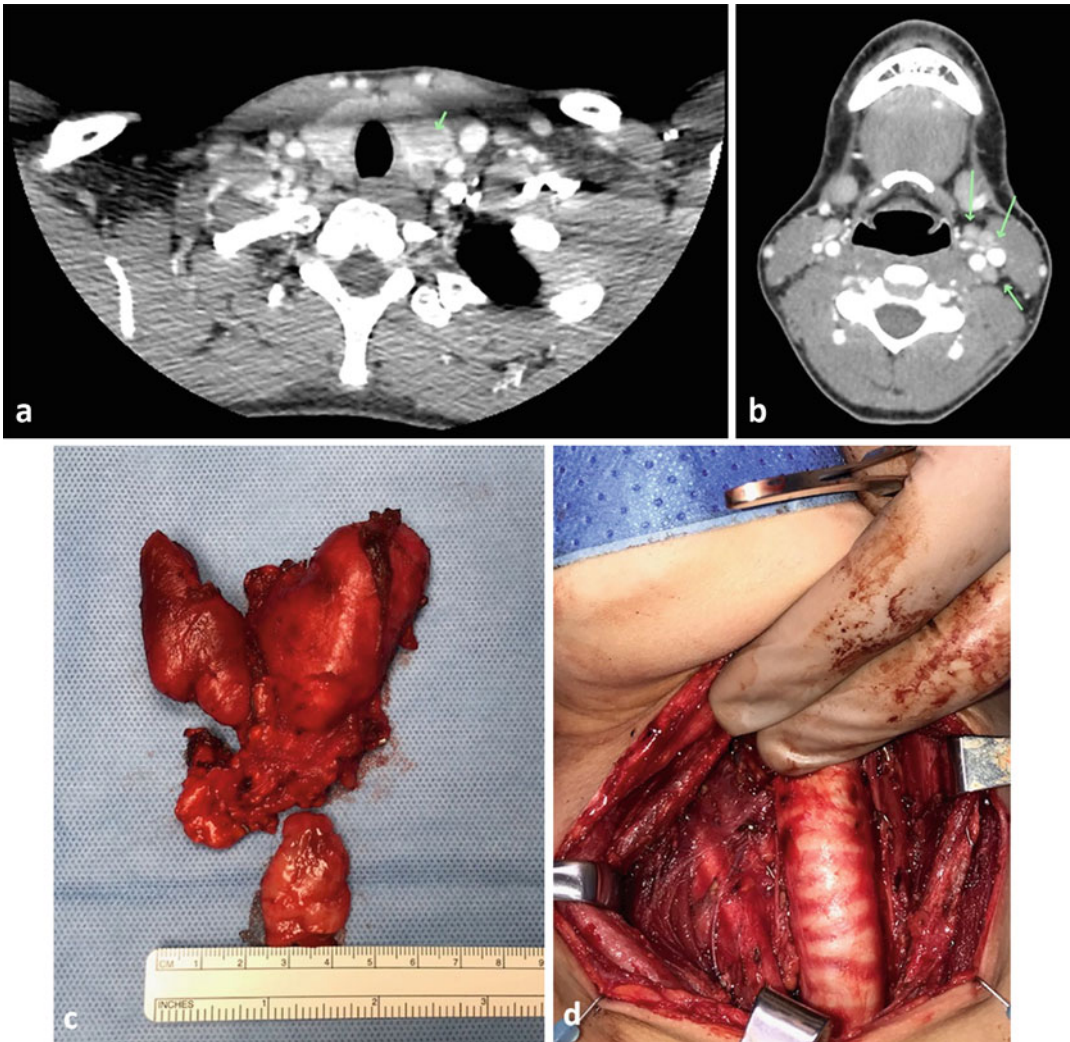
Papillary thyroid carcinoma in a 21-year-old female. CT shows a large left thyroid mass biopsied and shown to be papillary carcinoma (a). This is associated with extensive left level II, III, and IV adenopathy on the left (b). Total thyroidectomy and central neck dissection
